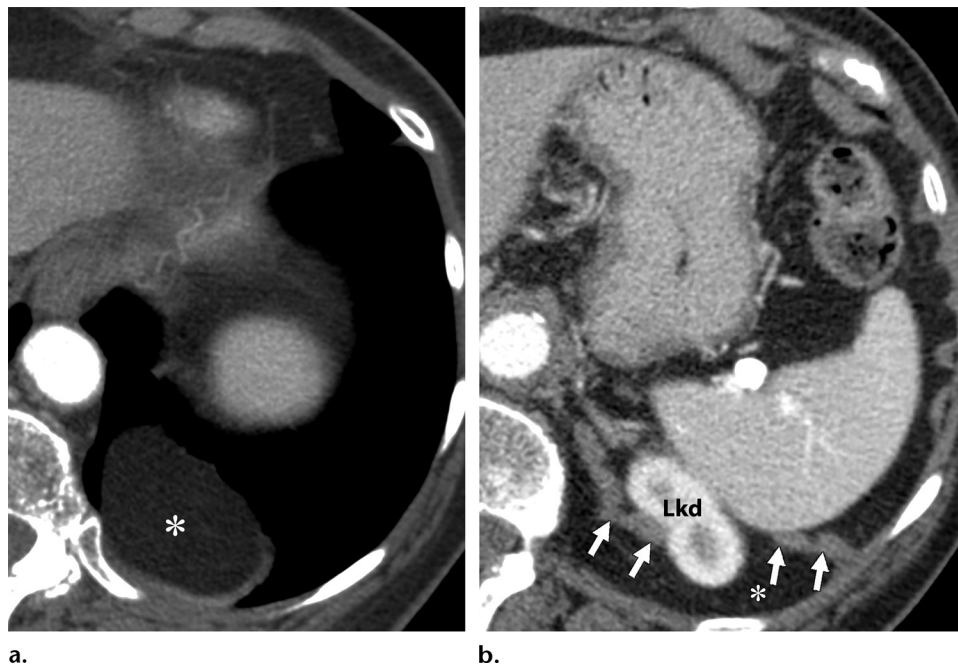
Posterior diaphragmatic defect mimicking focal thickening of the EPS. Axial CT images show intrathoracic herniation of retroperitoneal adipose tissue, manifesting as a localized increase in extrapleural fat (*). In b, a defect is seen in the posterior aspect of the left hemidiaphragm (arrows) in relation to a slight prominence of the contour of the superior pole of the left kidney (*Lkd*), which is slightly ascended.
